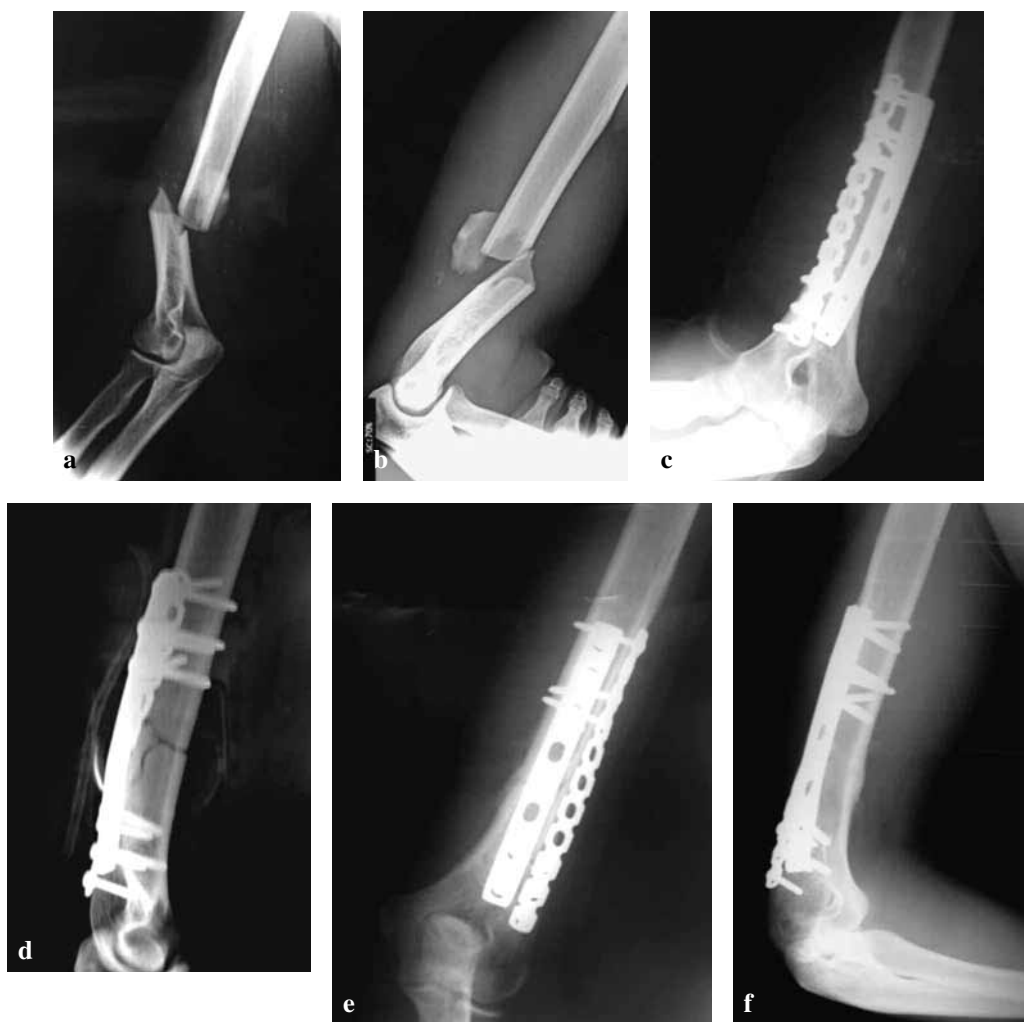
Case no 4 : a & b : preoperativeradiographs ; c & d : immediate postoperative radiographs ; e & f : 26 months postoperative.
